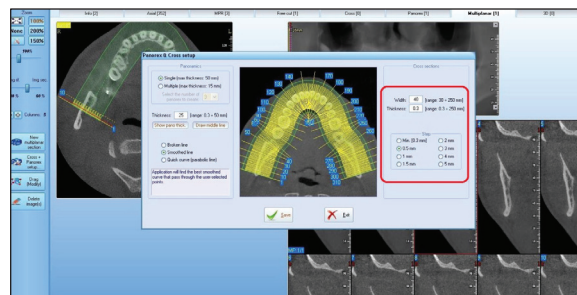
CBCT scan – cross-sections parameters.
